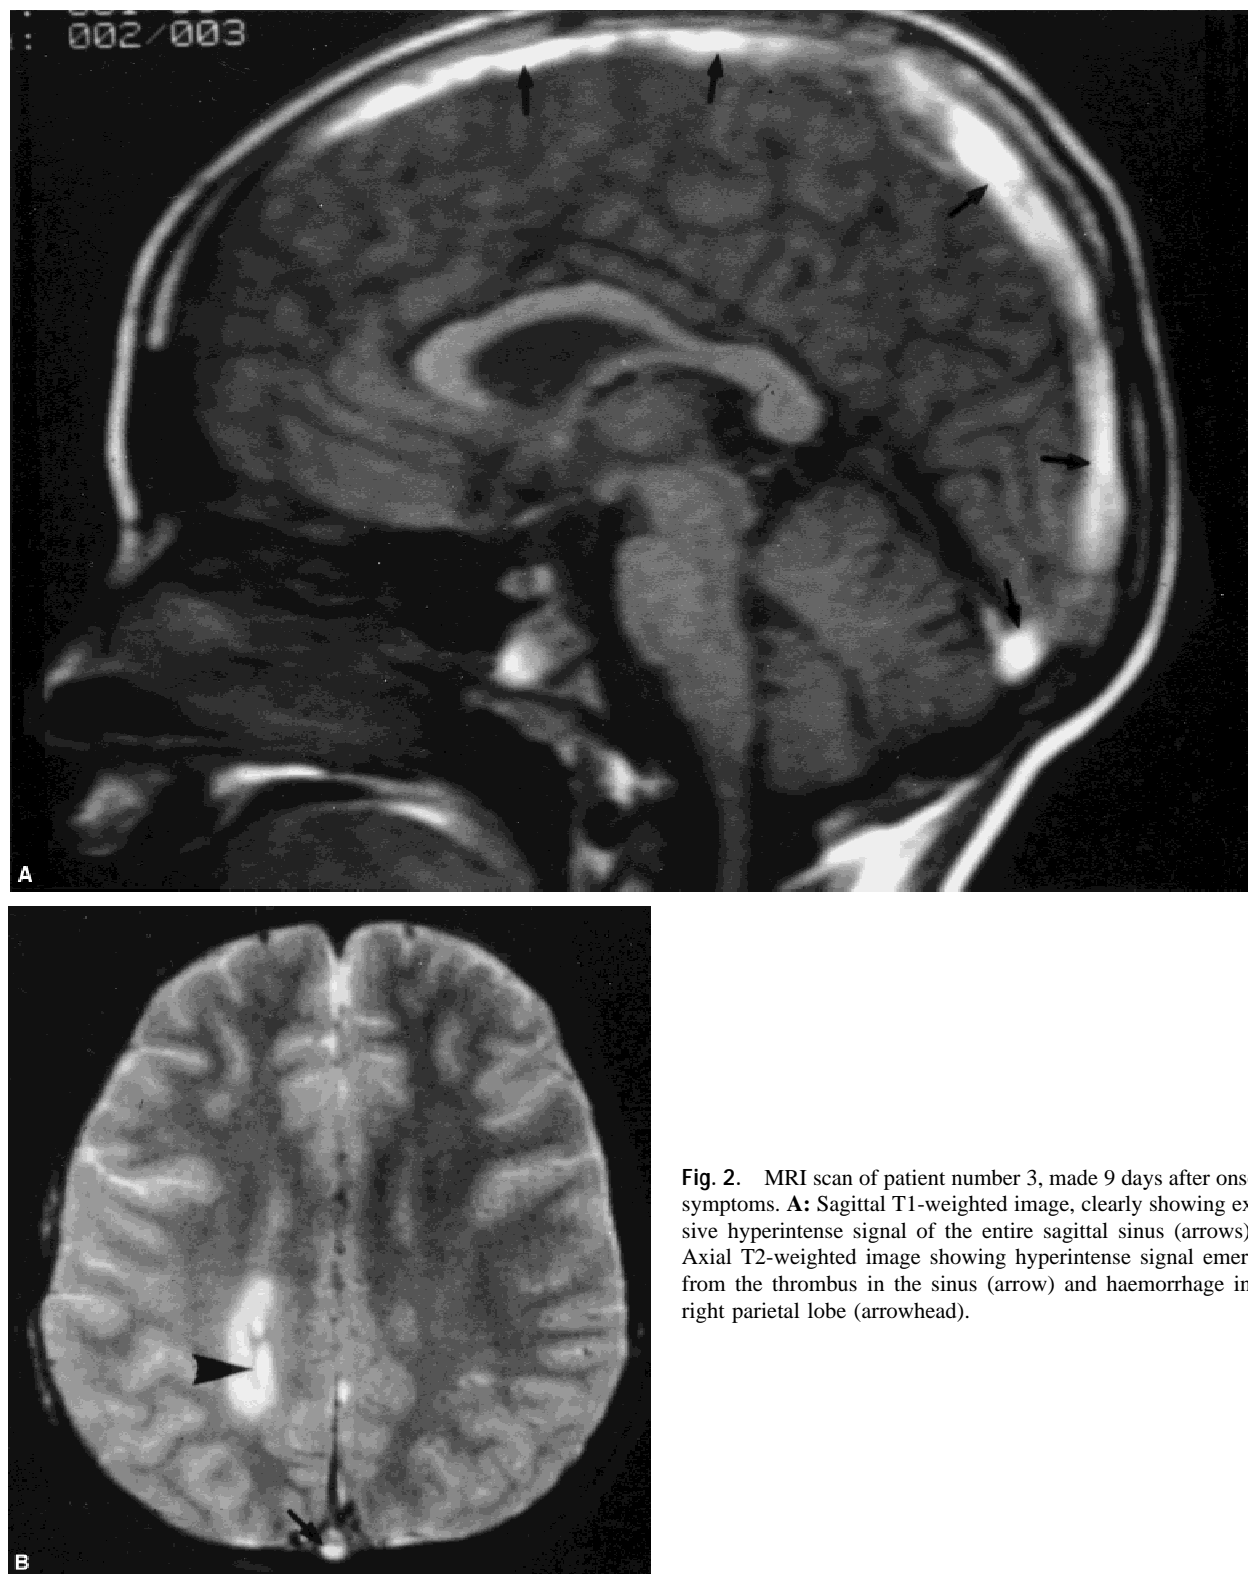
MRI scan of patient number 3, made 9 days after onset of symptoms. A: Sagittal T1-weighted image, clearly showing extensive hyperintense signal of the entire sagittal sinus (arrows). B: Axial T2-weighted image showing hyperintense signal emerging from the thrombus in the sinus (arrow) and haemorrhage in the right parietal lobe (arrowhead).
